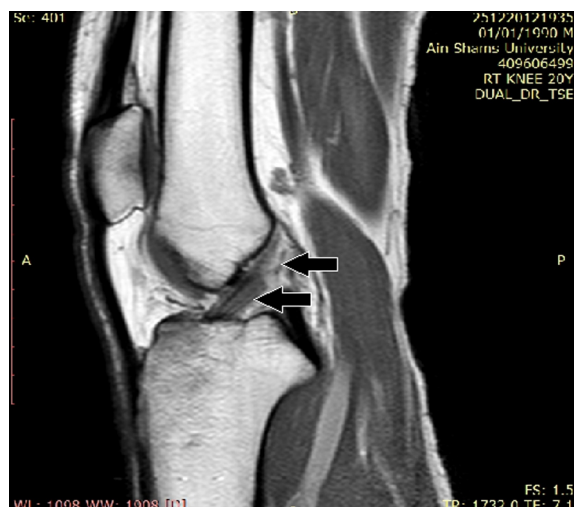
Sagittal T1W knee MR image demonstrating ACL partial tear. The ACL ligament is seen thickened, fuzzy with abnormal high signal intensity seen inside (arrows).
